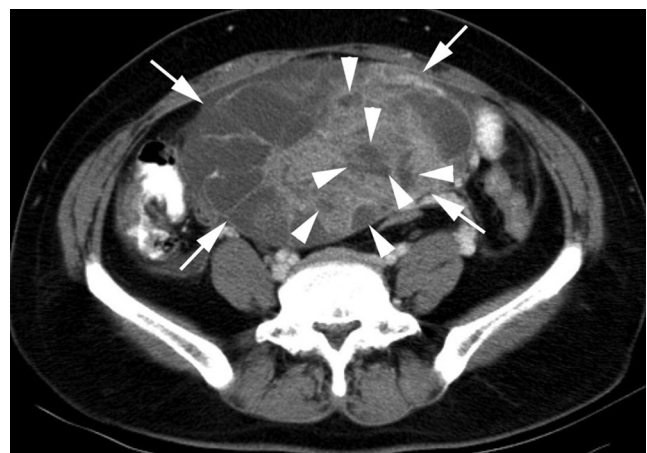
53-year-old female patient with poorly differentiated ovarian carcinoma. Transverse CT image shows mass with mixed pattern (arrows). Mass shows necrosis in the solid portion (arrowheads).
